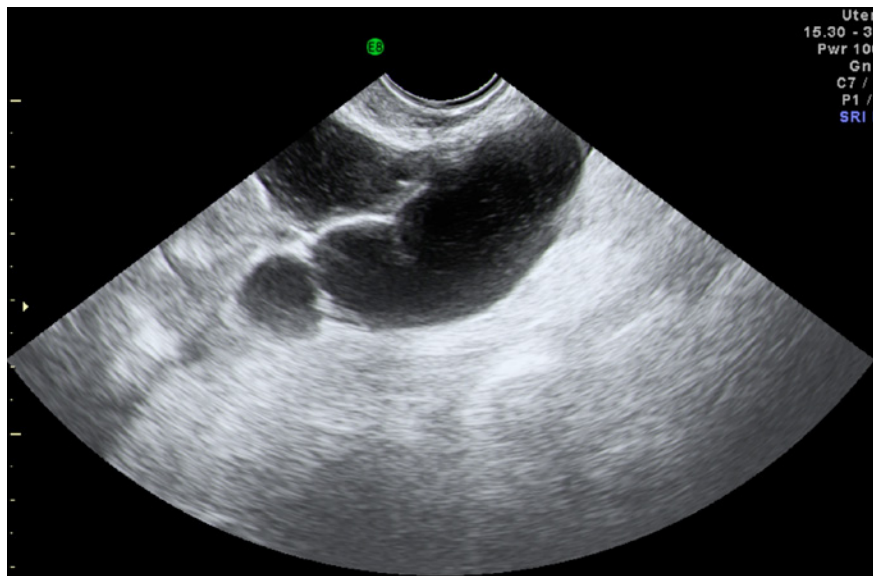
Ultrasound picture of a hydrosalpinx
